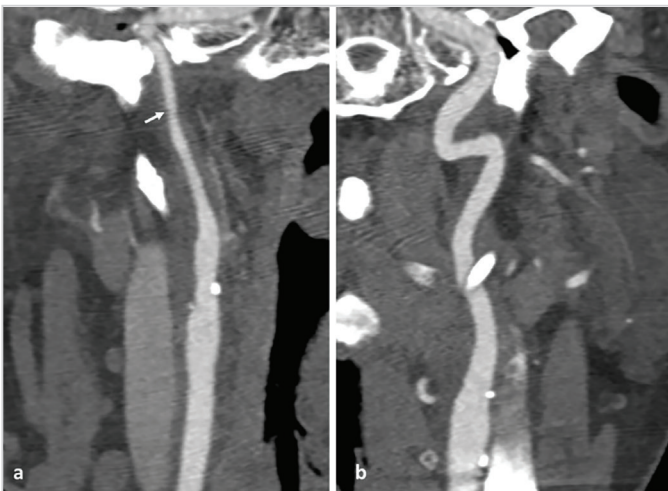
Computed tomography angiography reconstruction of the right (a) and left (b) internal carotid arteries, showing a diffuse thinned lumen in the former, suggestive of a carotid dissection (arrow), when compared with the contralateral carotid artery
